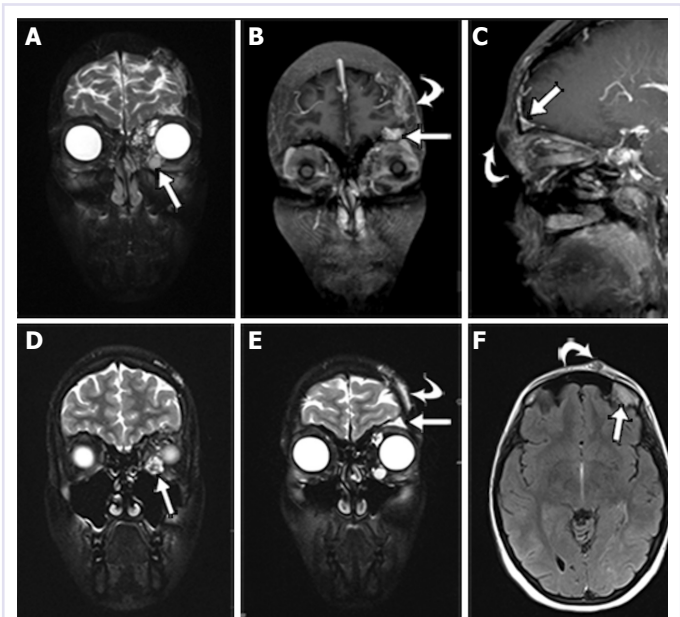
MIP coronal T2 fat-suppressed (A), and coronal (B) and sagittal (C) contrast-enhanced 3D MPRAGE reformatted images. Coronal T2 fat-suppressed (D, E) and axial FLAIR (F) images. Note a left inhomogeneous T2 hyperintense intra-orbital medial mass, consistent with a slow flow venous-lymphatic congenital anomaly (straight arrow in A, D), that was clinically visible as a lump of the left medial canthus. A bone hemangioma at the roof of the left orbit (straight arrow in B, C, E, F), sub-cutaneous fluid retention in the left frontal scalp (curved arrow in B, E) and thickening of the subcutaneous tissues in the left fronto-nasal skin (curved arrow in C, F).
